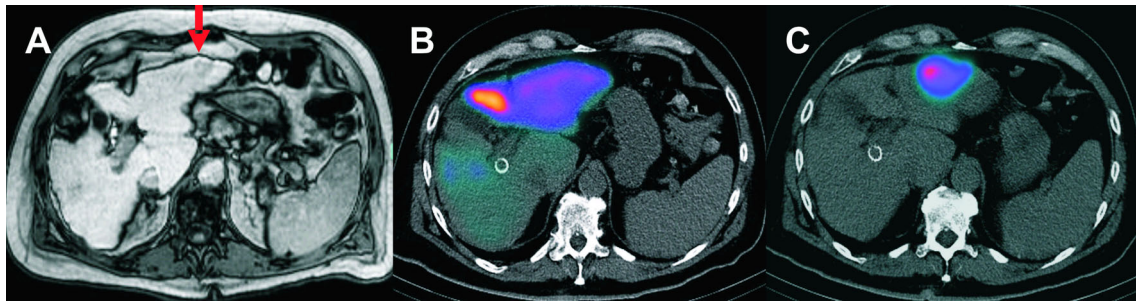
Patient with HCC in whom RE of a single HCC in the left liver lobe (a MRI scan, *red arrow*) was planned. The first test angiogram (b) shows diffuse tracer accumulation in the left liver lobe and no specific
